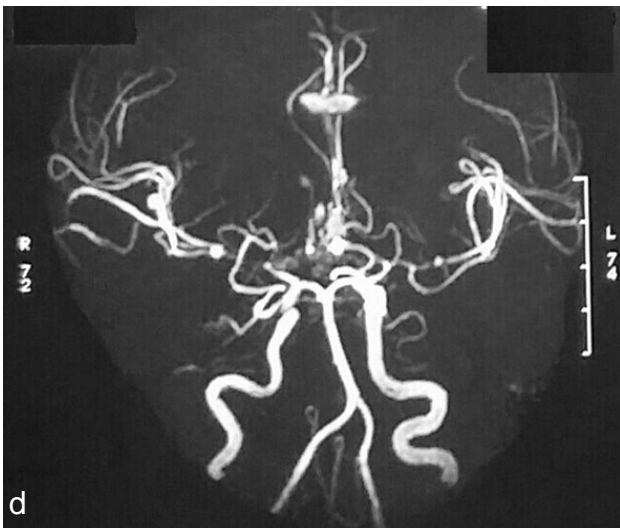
A case where a small aneurysm in the Anterior communicating artery was identified on 2D DSA (a) and 3D DSA (b) but CTA (c) and MRA (d) failed to demonstrate it.
